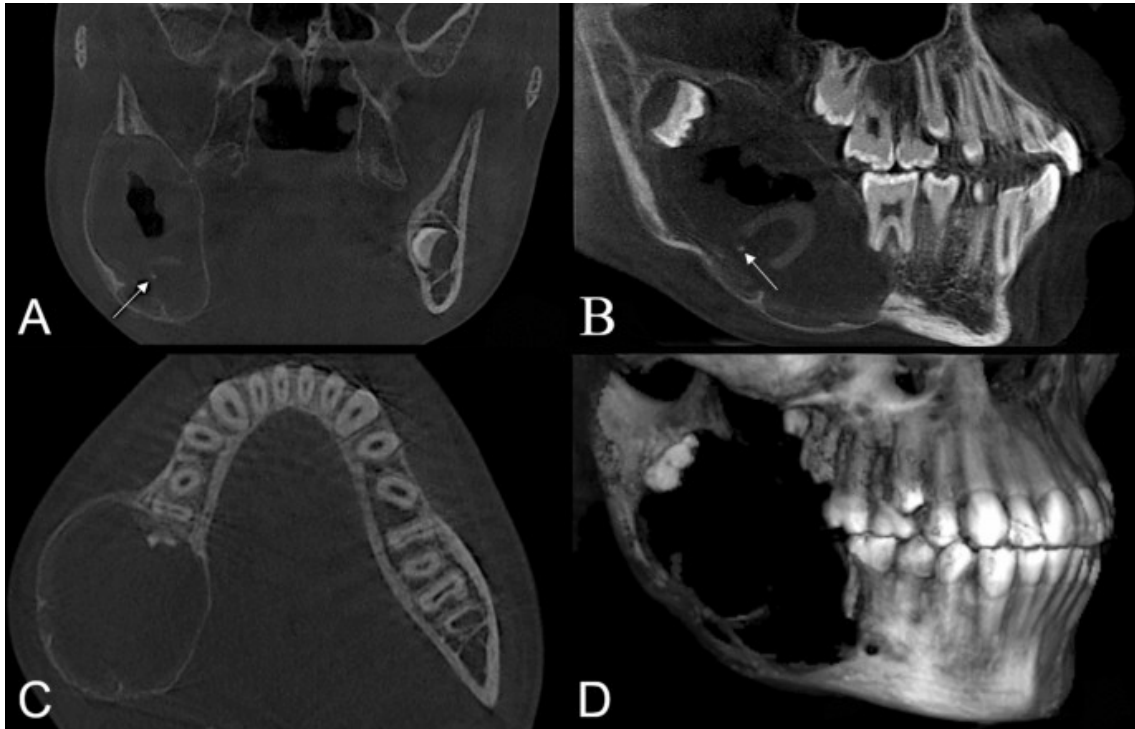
Coronal (A), sagittal (B), axial (C) and three-dimensional reconstructed (D) CBCT images showing a well-demarcated lesion with cystic and solid areas. Small internal calcifications were noted (arrow)
